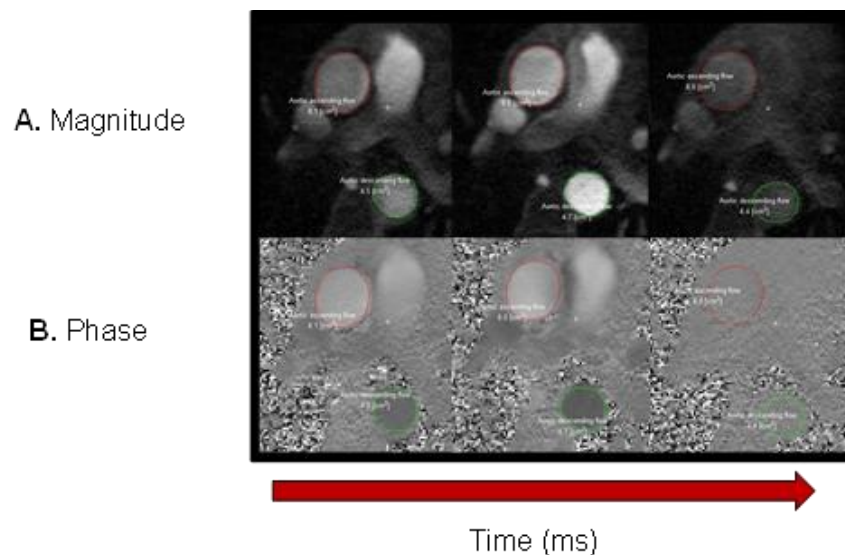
Phase contrast MRI: A. Magnitude and B. PC-MRI images acquired over a R-R cycle over 128 phases
